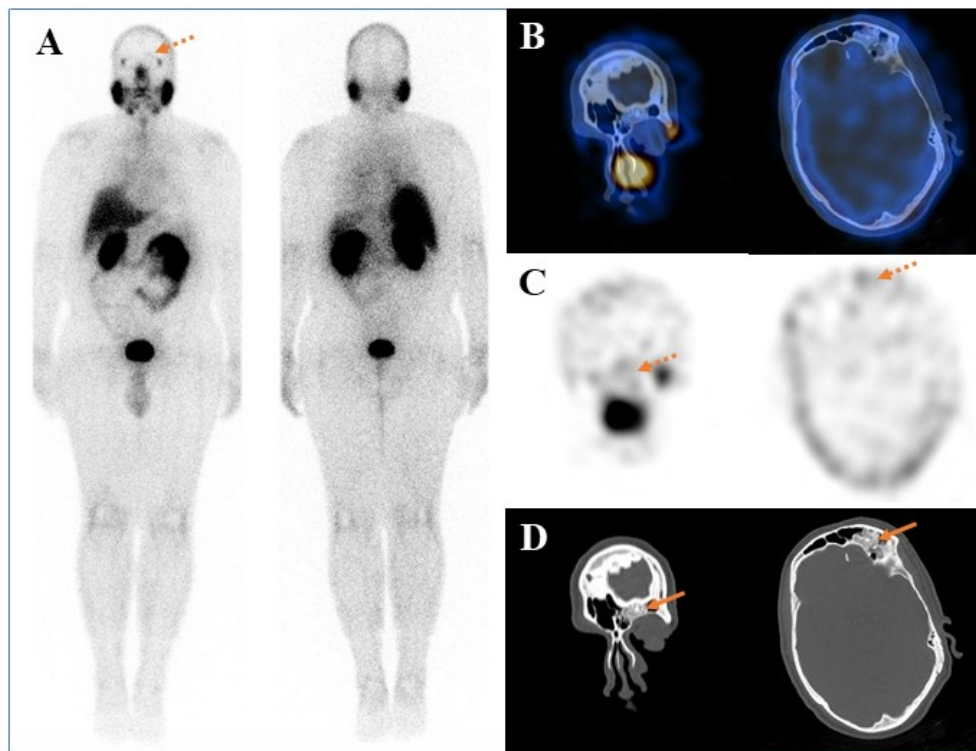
Planar whole-body PSMA imaging (A) and SPECT/CT images (B, C) demonstrated faint tracer uptake (dotted arrows) corresponding to a left frontal sinus osteoma identified on CT (D, arrows)
